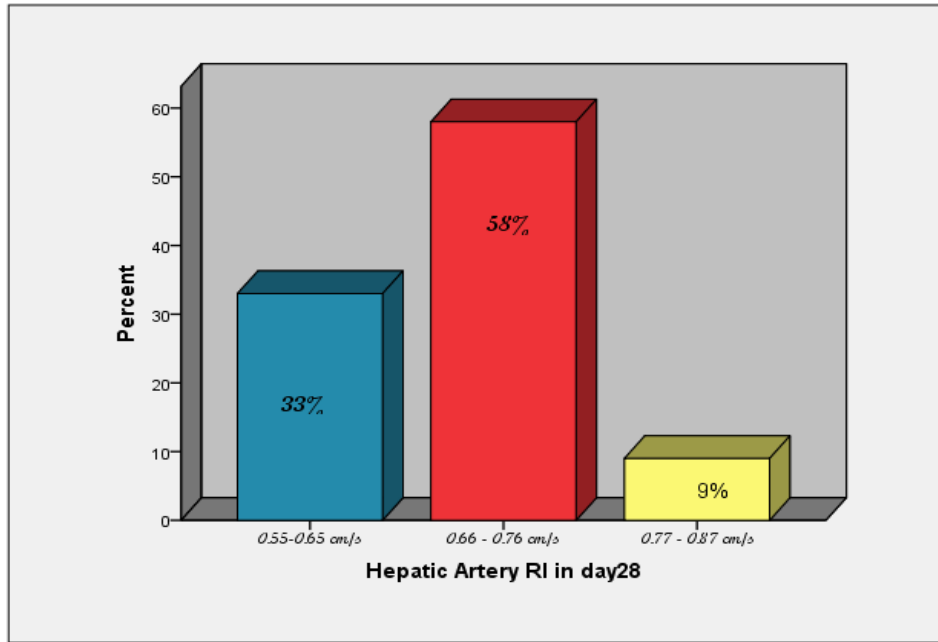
Frequency distribution of Doppler RI for hepatic artery in day 28
